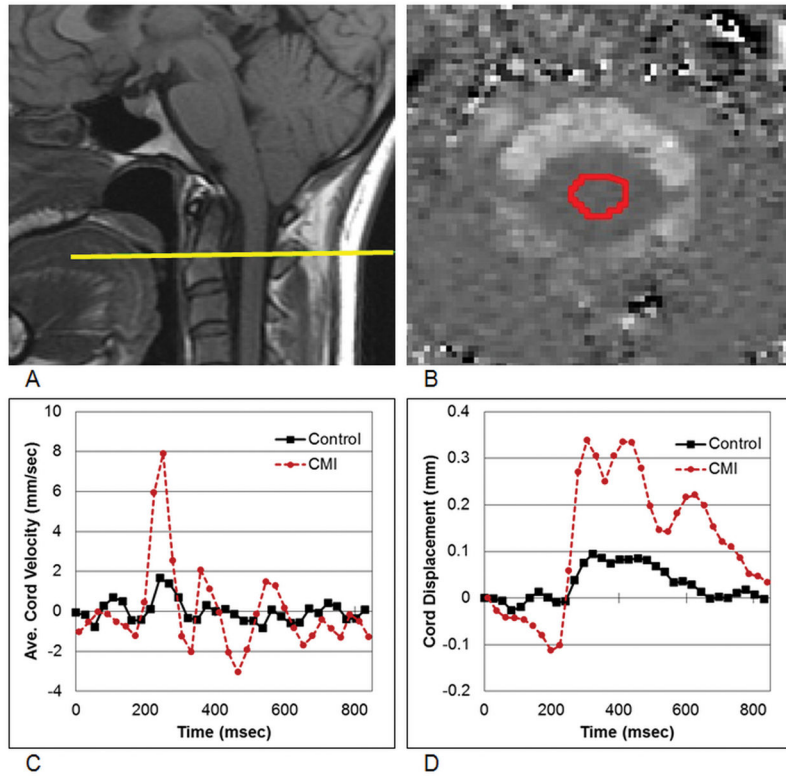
Measurements of cord motion dynamics. A) The imaging plane superimposed on the MRI mid-sagittal image in a CMI patient. (B) The cord region of interest superimposed on the MRI phase contrast velocity image. C) Average cord velocity waveforms for a representative CMI and control patient. D) Cord displacement waveforms from the representative CMI and control patient obtained by integration of the velocity waveforms with respect to time for one cardiac cycle.
